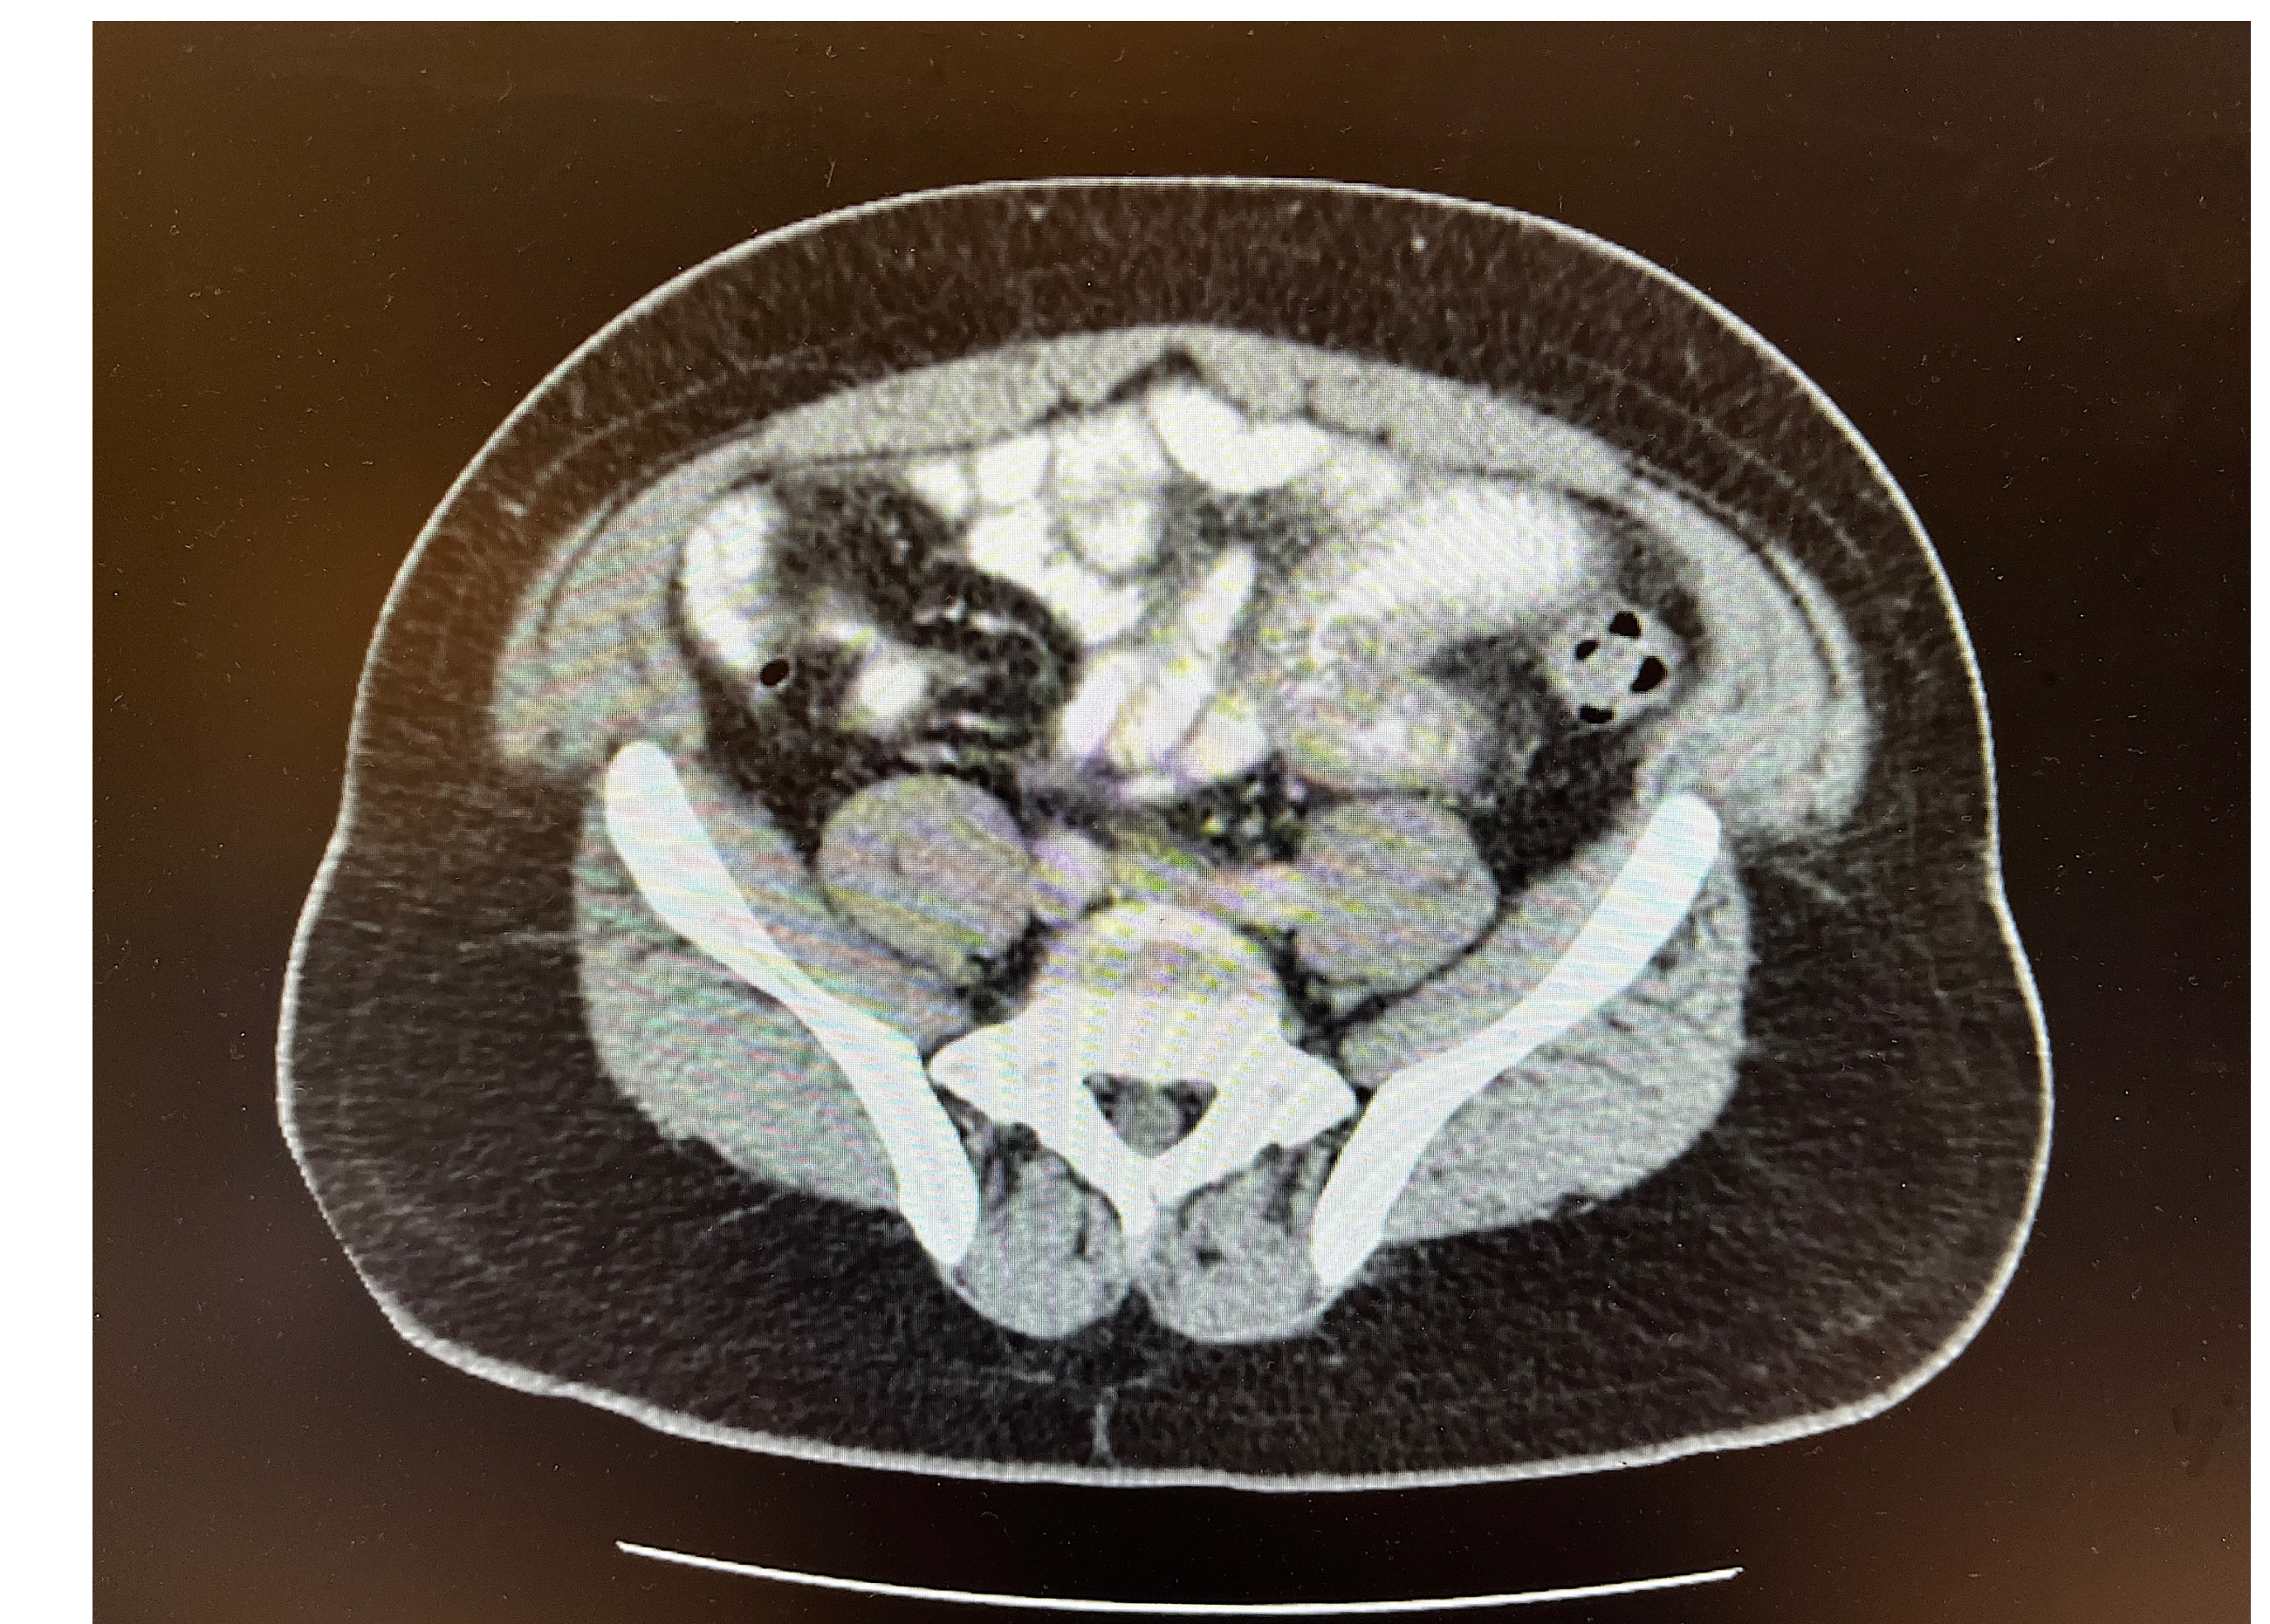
CT Abdomen/Pelvis with contrast obtained prior to discontinuing ACEi, emphasizing jejunal wall thickening.
